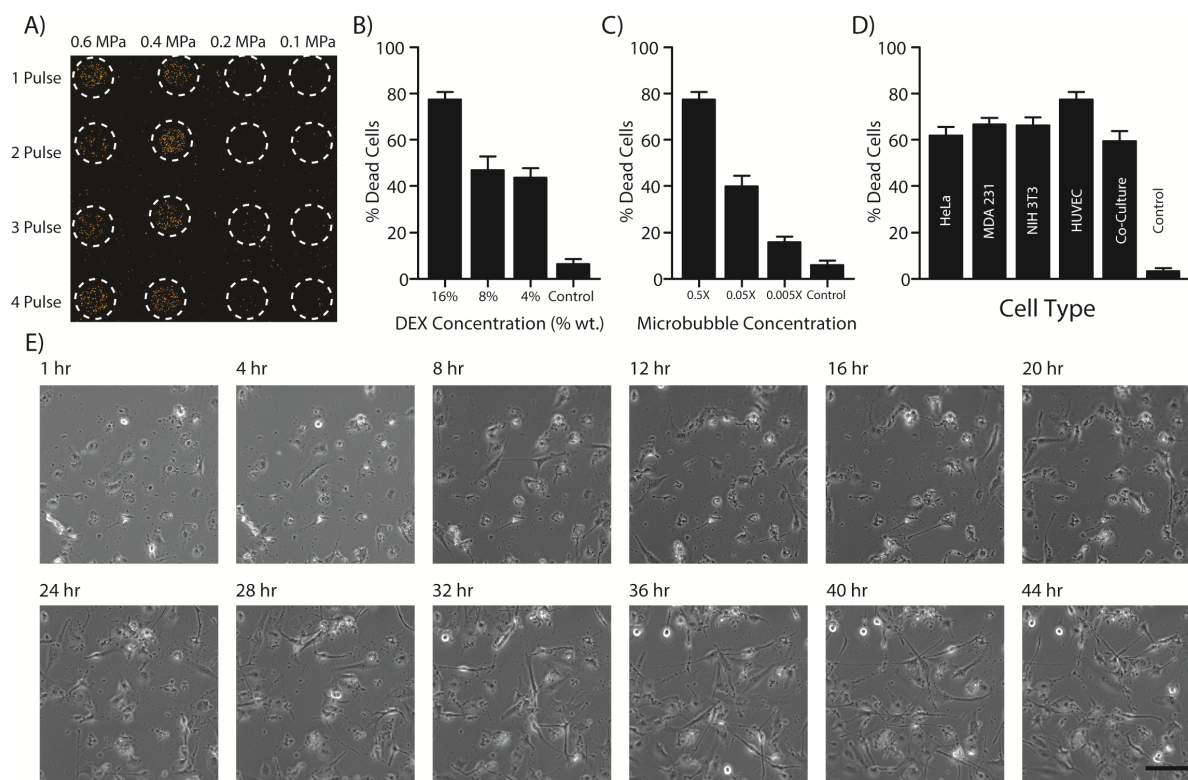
Optimization of ultrasound and microbubble conditions for targeted cell killing. (A) Placing DEX droplets in an array allows multiplexed testing of ultrasound parameters such as number of pulses (down) and pressure amplitude (across). The array image is a reconstructed mosaic from high magnification brightfield and PI images. Scale $\sim 500 \mu\text{m}$. Cell death was minimal at low pressures (0.1 and 0.2 MPa). Multiple low pressure pulses (3 or 4 pulses) resulted in a slight increase in cell death for the 0.2 MPa ultrasound condition. Pressures of 0.4 and 0.6 MPa resulted in a high proportion of cells dying in the patterned areas, with little effect from additional pulses. (B) Decreasing the DEX concentration resulted in microbubble aggregating. Cell death was markedly reduced at 8% and 4% DEX concentrations. (C) The proportion of dead cells decreased with decreasing microbubble concentrations. (D) HUVECs were most sensitive to microbubble excitation, but cell death was similar among all the cell types we tested. Control regions without microbubbles showed minimal cell death (data compiled for all cell types). Bars in (B-D) denote mean \pm SEM for $n=3$ independent experiments. (E) Time lapse imaging of microbubble targeted co-cultures of MDA231, NIH 3T3 and HUVECs showed that cell debris was gradually removed over the course of several days as the treated regions became repopulated by cells from surrounding untreated areas. Scale $\sim 60 \mu\text{m}$.
